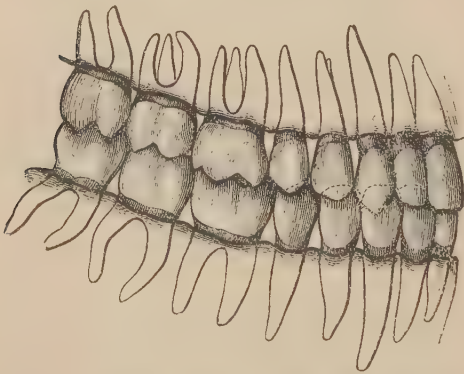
LABIAL ASPECT OF THE RIGHT HALF OF THE TWO DENTAL ARCHES TO SHOW THE RELATION BETWEEN THE UPPER AND LOWER TEETH. (Zuckermandl.)
